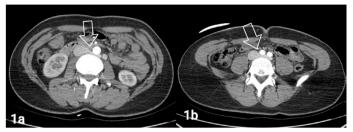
Contrast-enhanced axial upper abdominal CT scans in a 27-yearold female patient with a double RLRV variation. The more cranially located branch drains into the middle 1/3 infrarenal IVC segment, which is approximately the L2 - L3 disc level (1a). The more caudally located branch, on the other hand, drains into the left iliac vein, which is approximately at the L4 vertebra level (1b).
